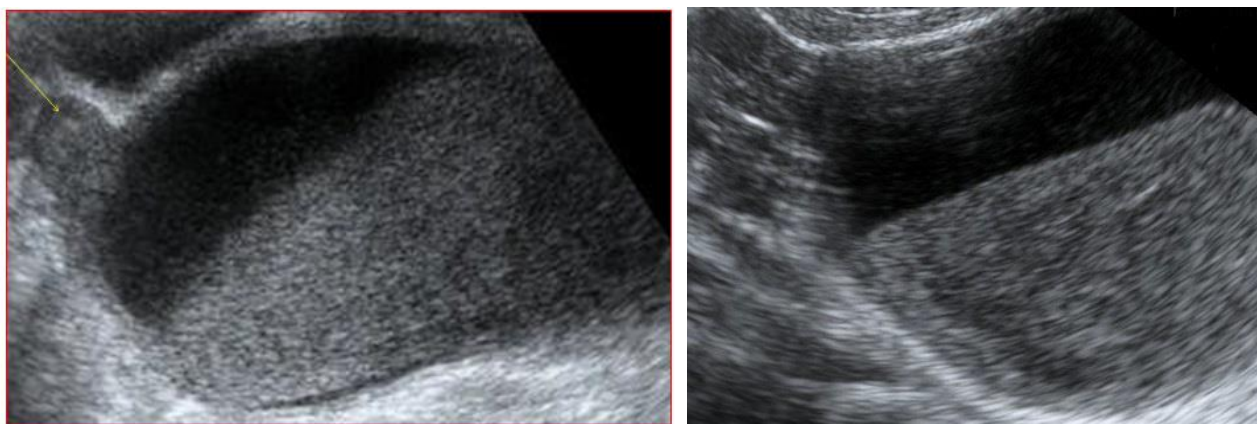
Pelvic ultrasonography: fluid structure extending inferiorly from the uterus to the vaginal with interior echos
